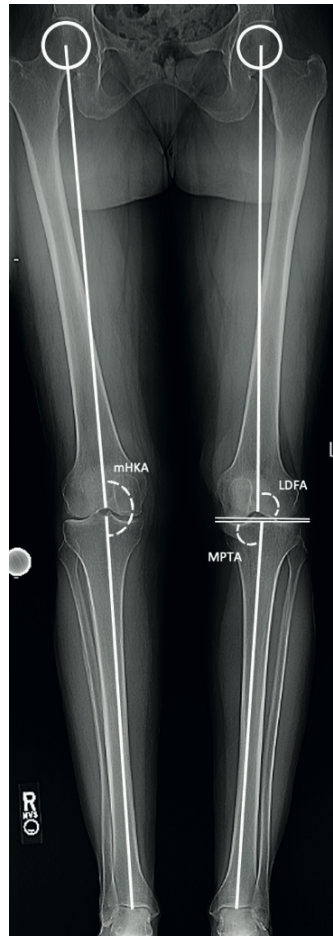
Long-leg standing anteroposterior (OA) radiograph. Measurement of the mechanical hip-knee-ankle angle (mHKA, the angle subtended by the mechanical axis of the femur and the mechanical axis of the tibia), medial proximal tibial angle (MPTA, the angle subtended by the mechanical axis of the tibia and the proximal tibial joint line) and the lateral distal femoral angle (LDFA, the lateral angle subtended by the mechanical axis of the femur and the distal femoral joint line).
